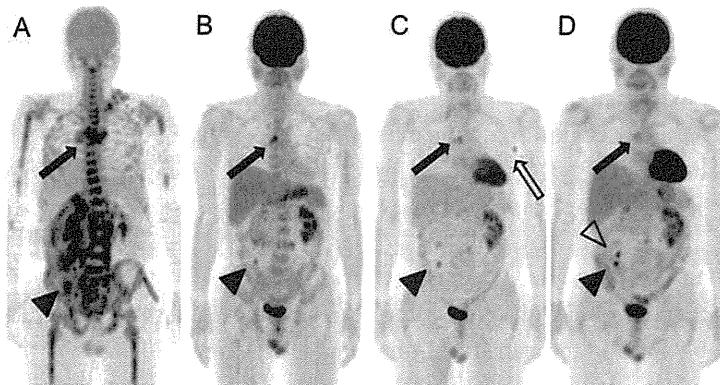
A. The pretreatment PET/CT shows FDG avid lesions at the mediastinum (arrow), cecum (arrow head). Interim (B) and follow up (C, D) PET/CT shows residual FDG uptake at both lesion. New FDG uptake appears at left axilla (C, white arrow) but disappeared (D), considered as HIV-related lymphadenopathy. New FDG uptake at cecum was caused by infection of tuberculosis (D white arrow head).
